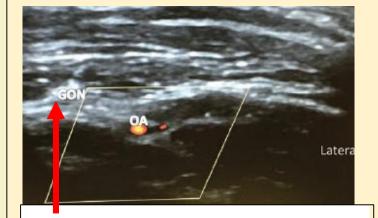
Identification of the greater occipital nerve (GON) and the occipital artery (OA) via ultrasound.
